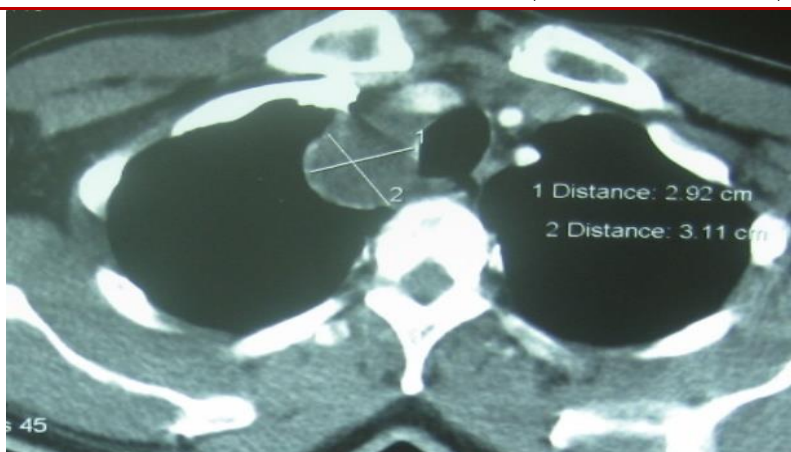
Thoracic CT scan showed mediastinal lymphadenopathy suggestive of ganglionic tuberculosis
